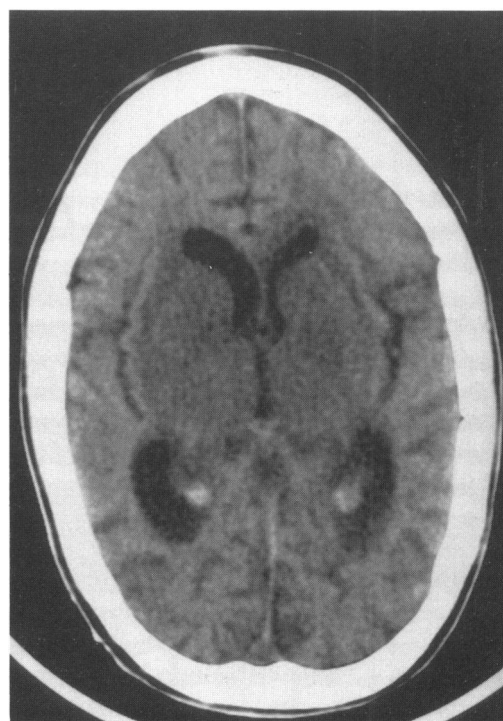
Brain MRI of AU. *Above*, Imaging revealed generalized cerebral atrophy, ventriculomegaly, and severe OPCA (arrows). Sagittal T₁-weighted spin echo TR = 800 and TE = 20. *Top right*, Extensive abnormal signal throughout white matter of cerebral hemispheres, consistent with leukodystrophy. Axial T₂-weighted spin echo TR = 2,000 and TE = 80. *Bottom right*, Brain CT of GU. Generalized cerebral atrophy, ventriculomegaly, and severe OPCA were again seen. No intracranial calcifications characteristic of CS were observed.
